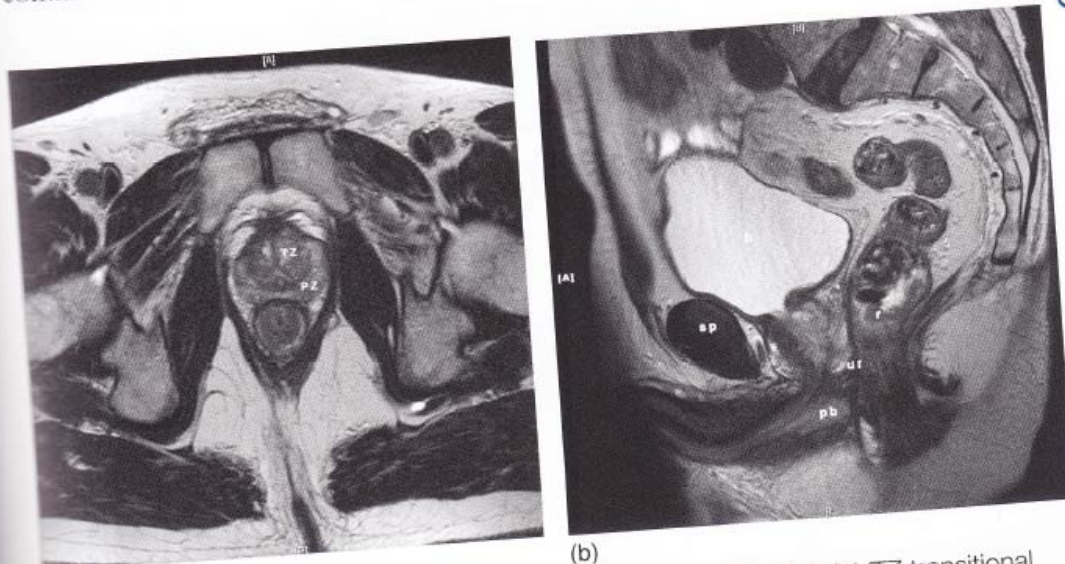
Anatomy of prostate shown on T2-weighted MRI. (a) Axial (TZ transitional zone, PZ peripheral zone). (b) Sagittal (pb, penile bulb; b, bladder; sp, symphysis pubis; r, rectum; df, Denonvilliers' fascia).
